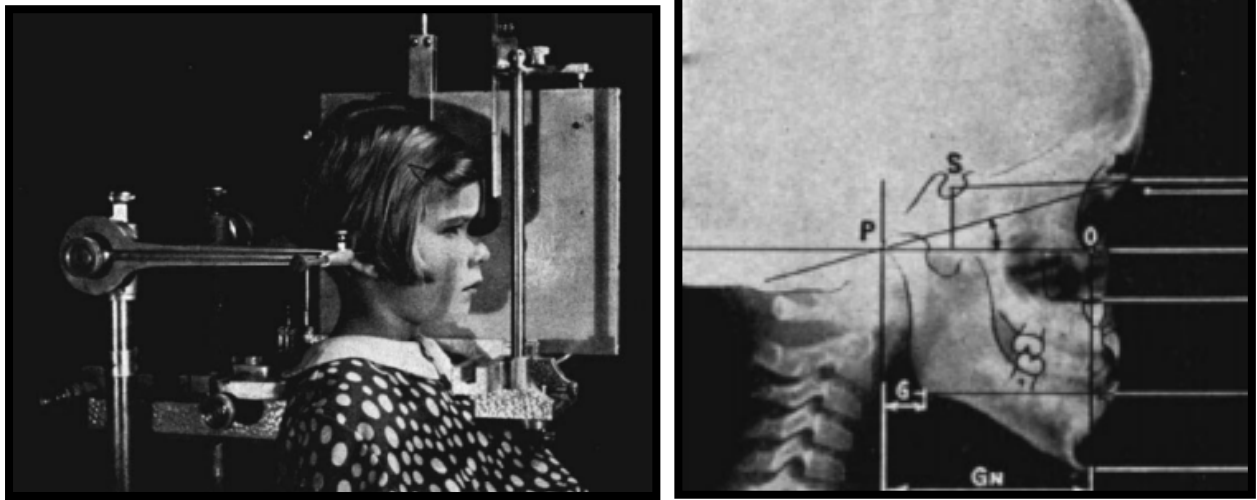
(Adapted from Broadbent et al)<sup>3</sup> The child's head adjusted to the Broadbent Head Holder for lateral roentgenogram (left). Lateral roentgenogram of a child with a developing Class III malocclusion shown with tracing of hard-tissue landmarks (right).
